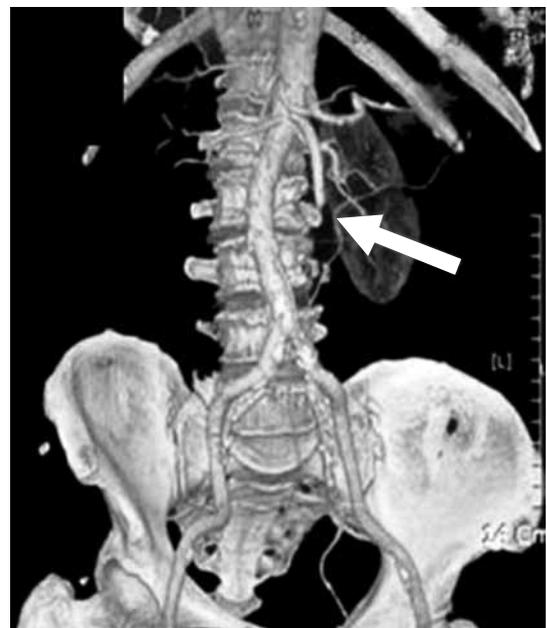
Computed tomography angiography showing the filling defect at the middle and distal portion of the superior mesenteric artery (arrow).
